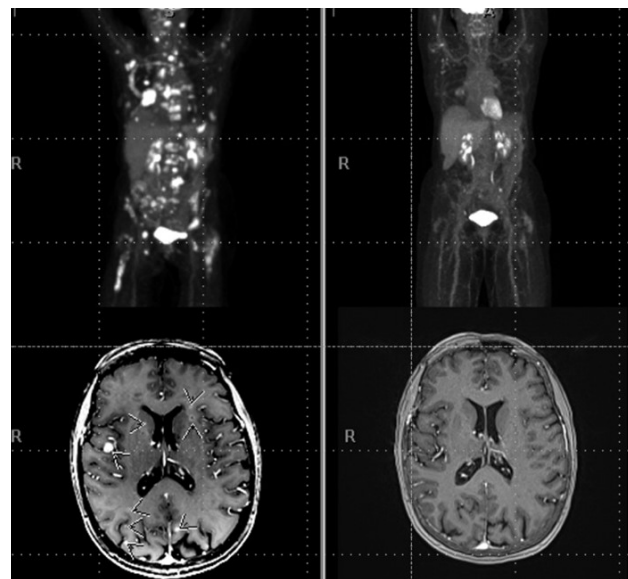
A 64-year-old female never smoker was found to have widespread EGFR mutation+ non-small cell lung cancer. Images at left show the initial PET scan and brain MRI, which had several dozen small lesions, some marked by arrows in this slice. The images at right show a sustained cranial and extracranial complete response after 18 months of osimertinib.
